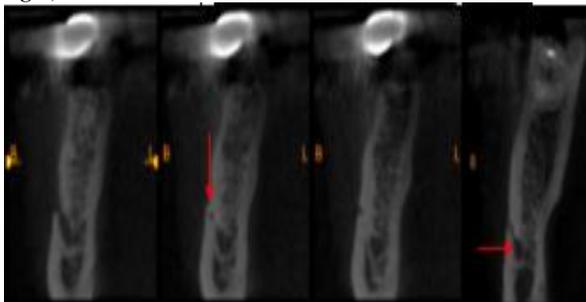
Cross-sectional CBCT slices showing the mental foramen (first slice on the left), the accessory mental canal through the buccal cortical plate (second slice from the left) and the accessory mental foramen (first slice from the right)
